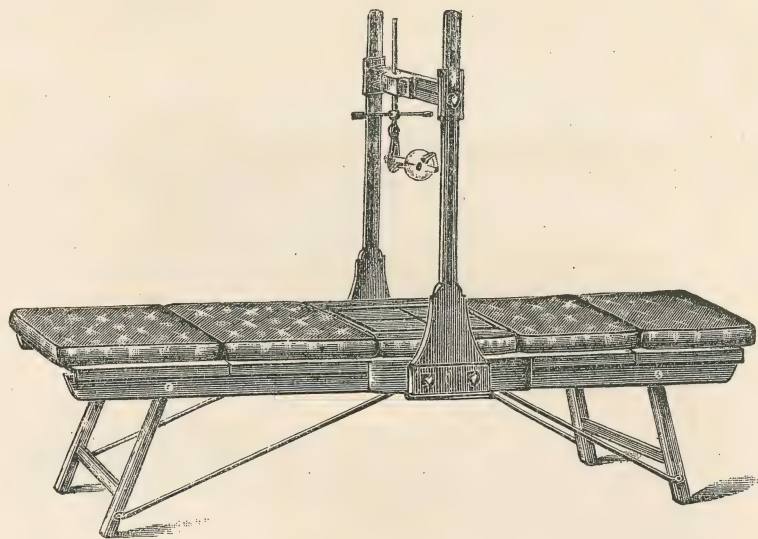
Example of X-ray examination table with sliding tube-carrier and cross-bar. The top is removable in sections, and the square seen under the tube and marked in quadrants can be shifted to center the plate in any other desired situation on the table. The millimetre scale on the cross-bar and the sliding adjustments of the tube-holder assist accurate work. It is one of the best and simplest tables made.
